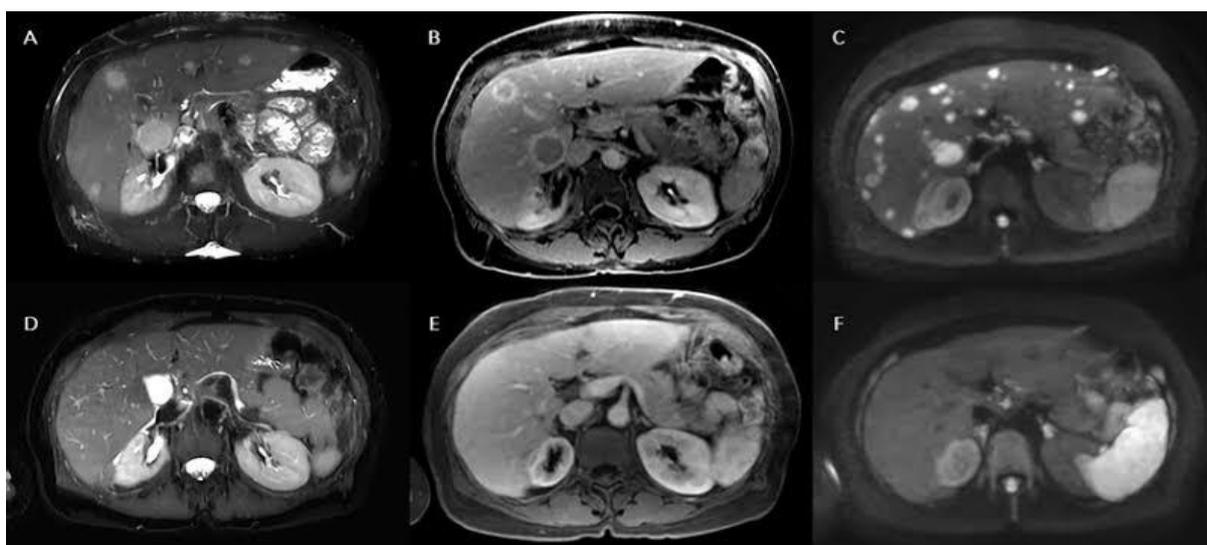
Liver metastases at MRI exam. Axial plane images showing multiples liver metastasis in both hepatic lobes (upper images) at T2 fat-sat (A and D), portal-phase post-contrast T1 fat-sat (B and E) and diffusion-weighted images (C and F).
